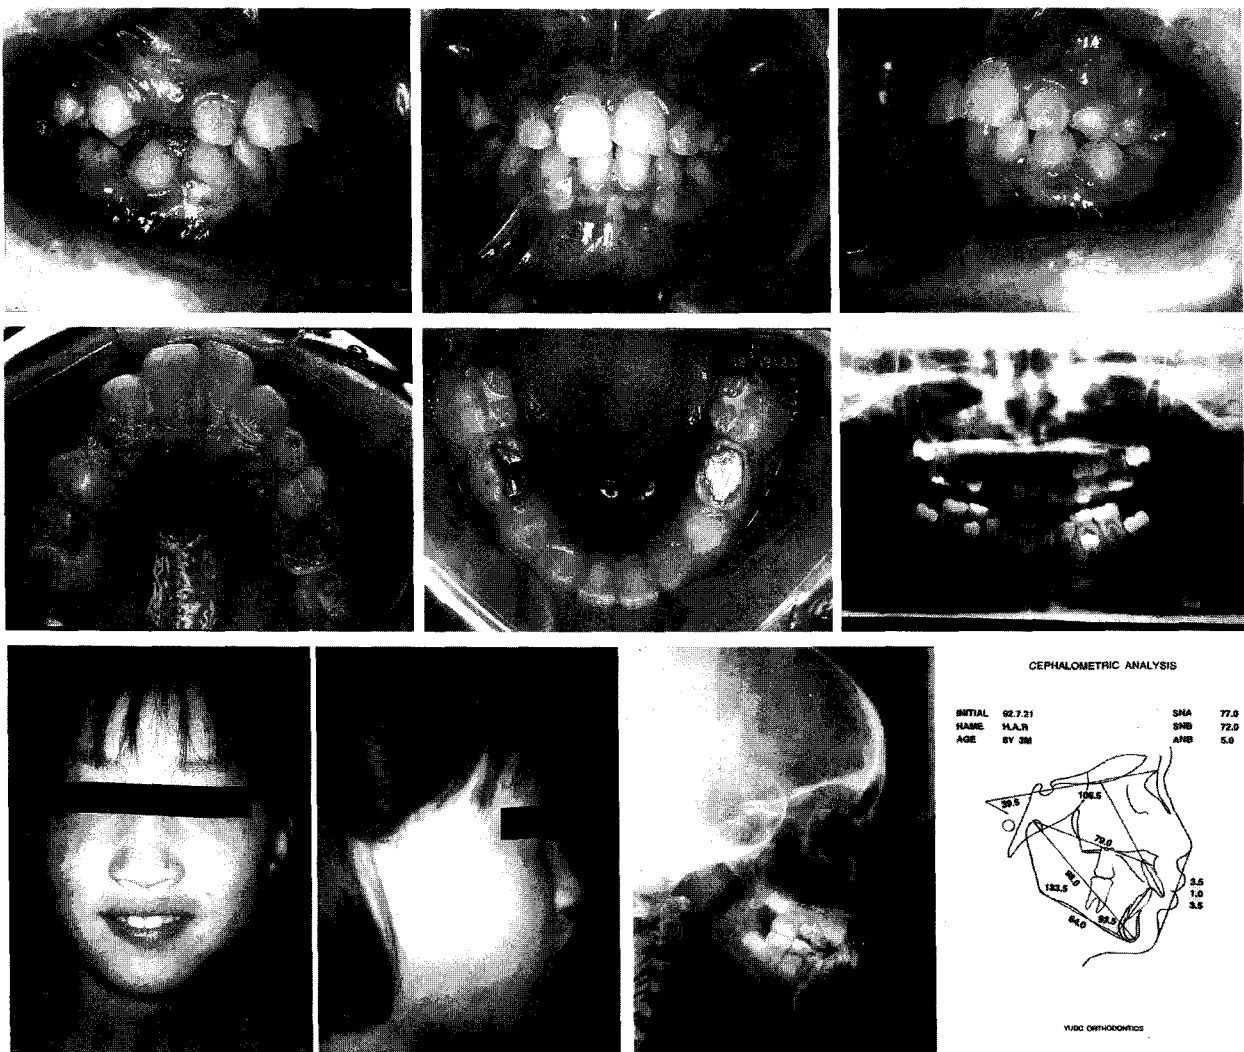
Pre-treatment intraoral, extraoral photos and X-ray of case 2
